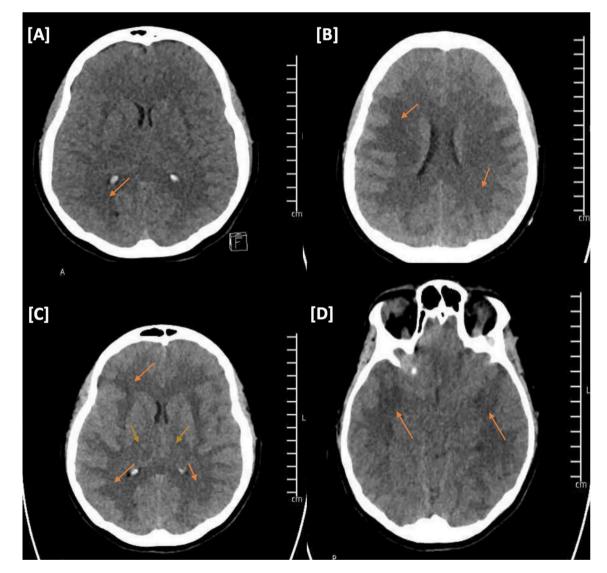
CT head none contrast enhanced.
